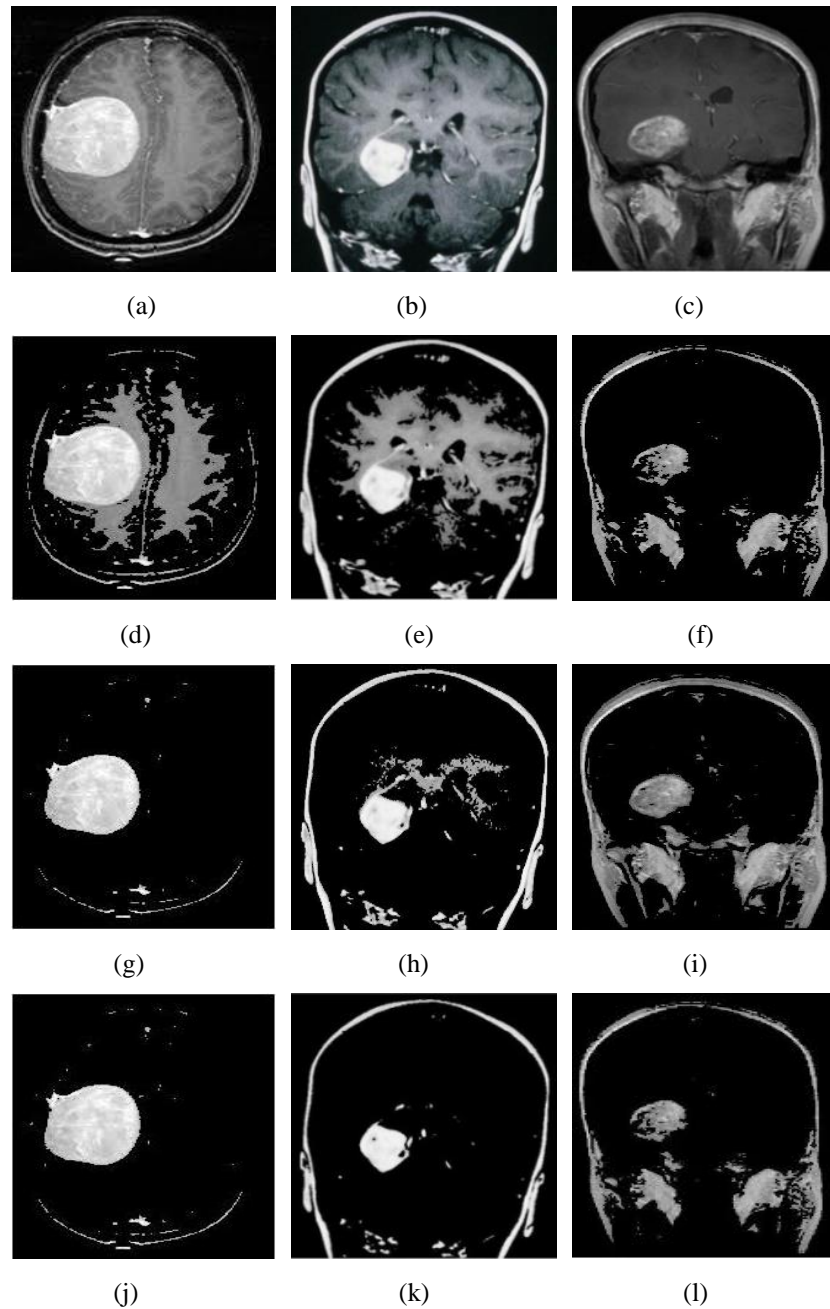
16 (left to right) (a, b, c): MRI brain image obtained from Figshare dataset; (d, e, f): segmented output images by proposed CBSS GC segmentation technique; (g, h, i): Segmented output images by proposed KMSS GC segmentation; (j, k, l): Segmented output images by proposed Fuzzy GC segmentation
